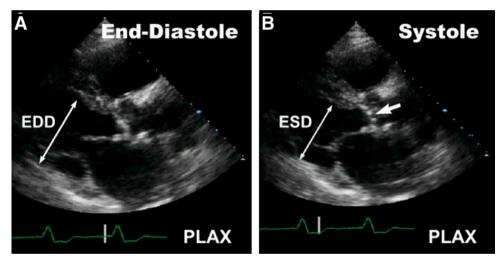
Aortic stenosis showing restricted leaflet opening (arrow) during systole (parasternal long-axis view [PLAX]). Left ventricular ejection fraction was reduced, hence "low stroke volume-low gradient" aortic stenosis. (Please *see* companion DVD for corresponding video.)
